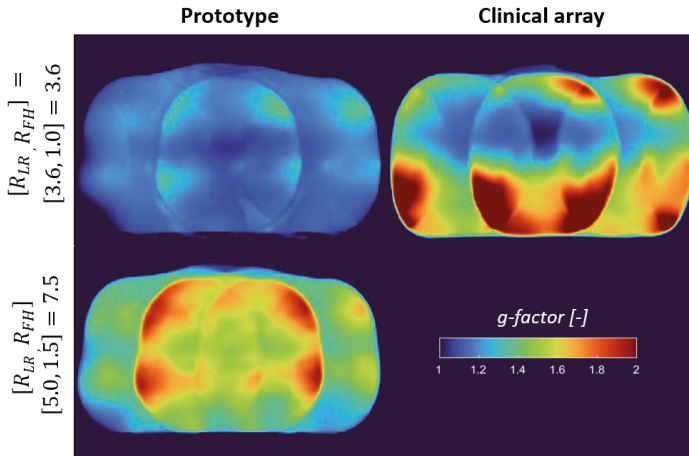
In-vivo g-factor maps from the clinically used MRI sequence (top row) and highly accelerated acquisition. Values are substantially lower when the prototype array is used, even when the scan time is reduced by more than half.
